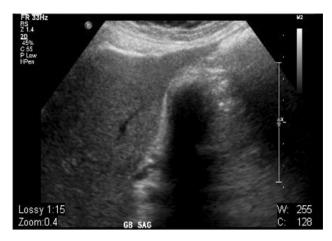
Transabdominal right upper quadrant ultrasound of the patient in Case 1 showing the wall echo shadow triad. All three cases had similar ultrasound findings
